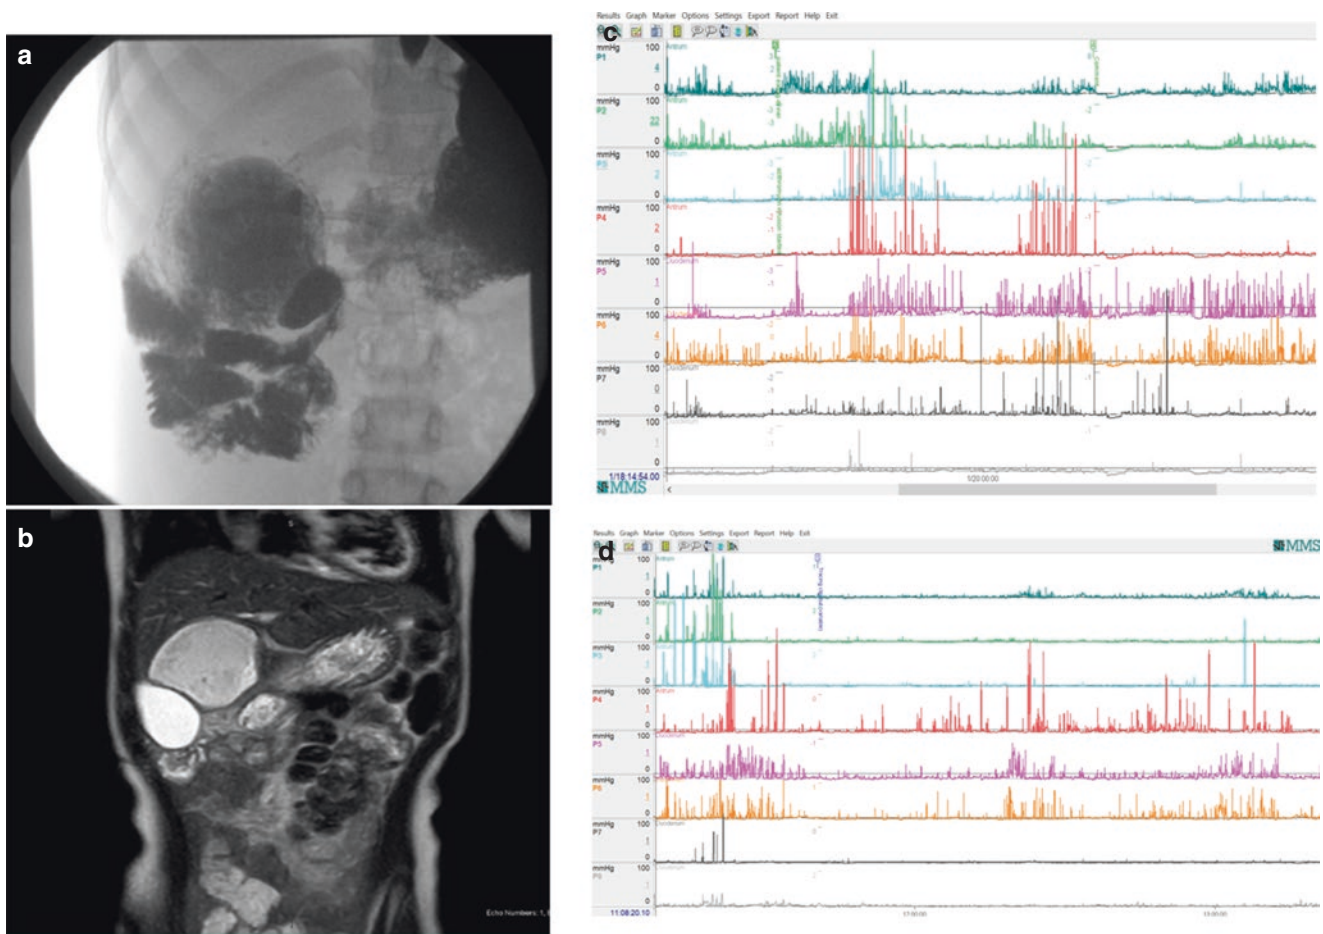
Disorganized duodenal motility in an 8-year-old boy with annular pancreas and gastrojejunostomy (a, b). Presence of dilated duodenum with blind loop in upper gastrointestinal series and MRI
